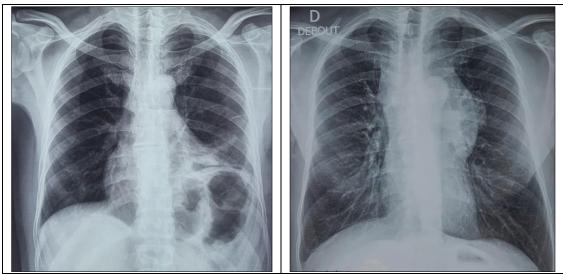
Front thoracic X-ray before/after complete surgical resection of mediastinal thymic cyst
